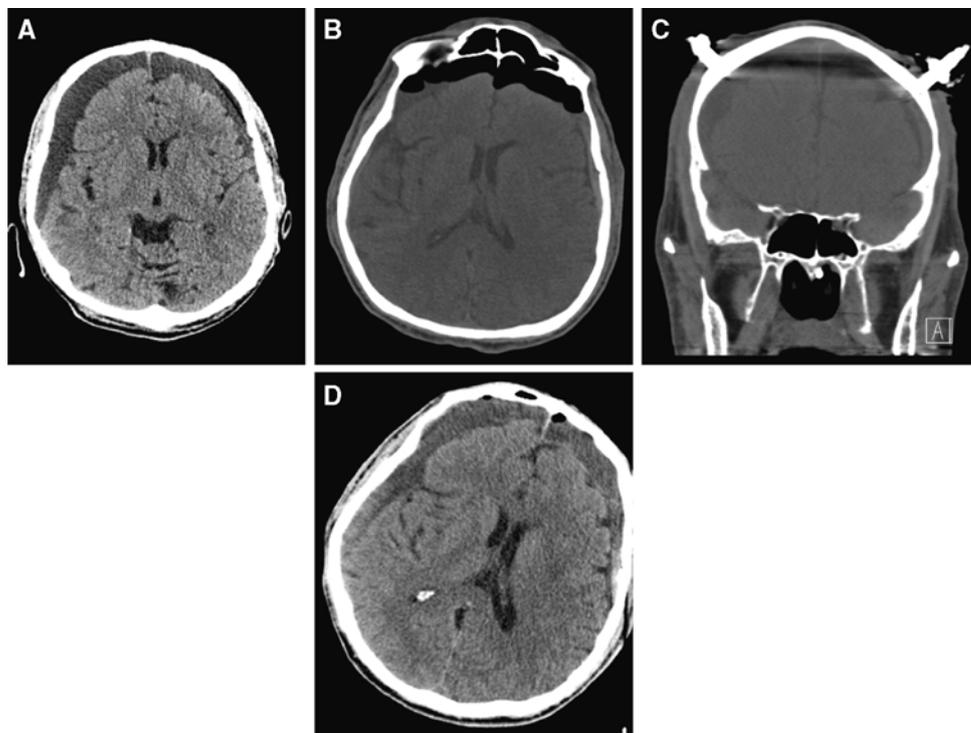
Case 1. Postoperative axial brain CT scans of the 53-year-old man who underwent transphenoidal resection for pituitary adenoma demonstrating the “Mount Fuji sign” (a) and the “air bubble sign” (b)
